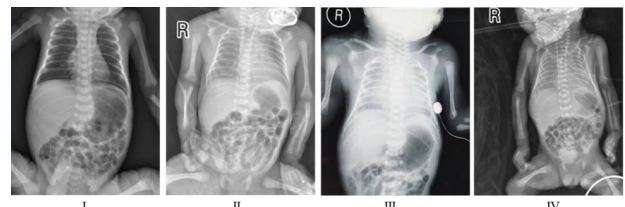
X-ray solography of varying degrees of respiratory distress.
